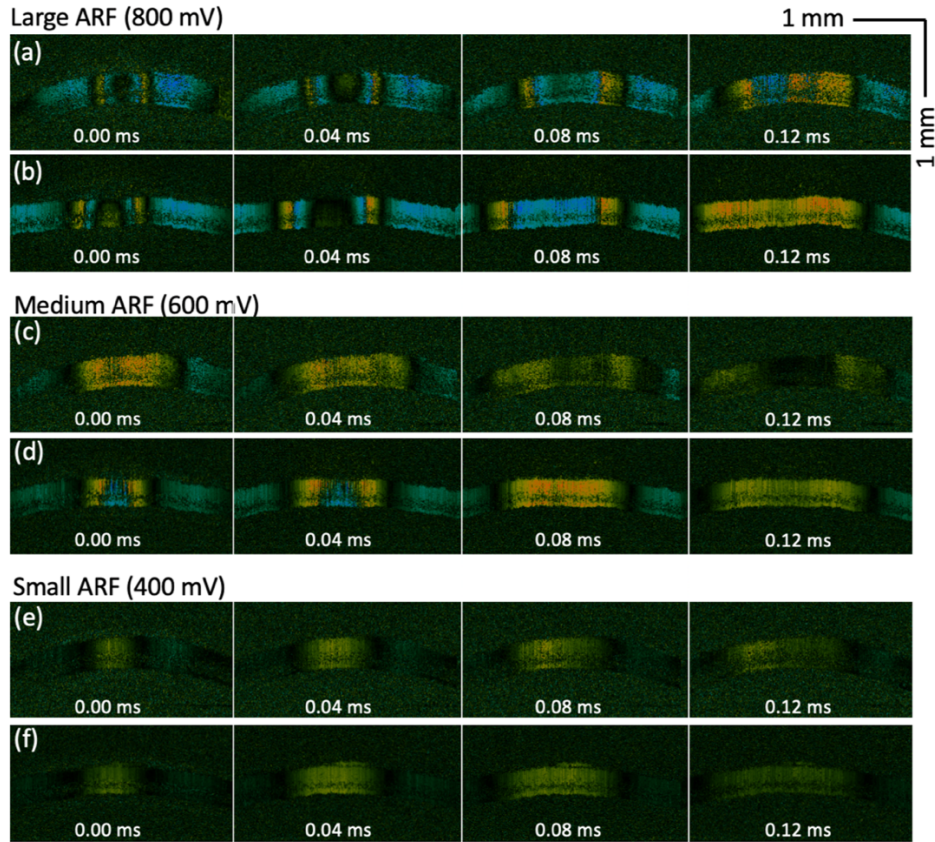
Time-lapse Doppler OCT B-scans from SS-OCE<sub>COV</sub> and SS-OCE<sub>CP</sub> system with different ARF. (a), (c), and (e) Time-lapse Doppler OCT B-scans from SS-OCE<sub>COV</sub> system with large, medium, and small ARF, respectively. (b), (d), and (f) Time-lapse Doppler OCT B-scans from SS-OCE<sub>CP</sub> system with large, medium, and small ARF, respectively.
